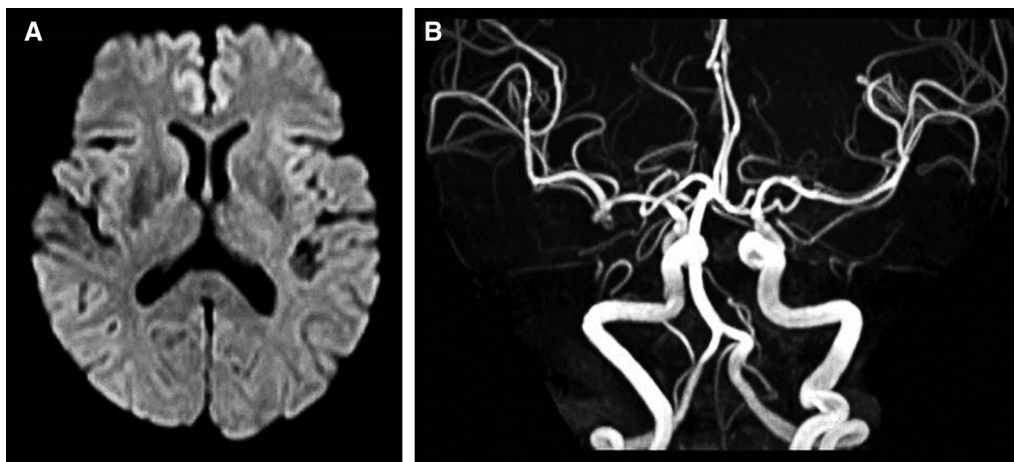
(A) Diffusion-weighted MRI the day after surgery did not show cerebral infarction. (B) On MRA the day after surgery, the aneurysm was not visualized. The ICA and DMCA were visible. DMCA: duplicated middle cerebral artery; ICA: internal carotid artery; MRA: magnetic resonance angiography; MRI: magnetic resonance imaging
